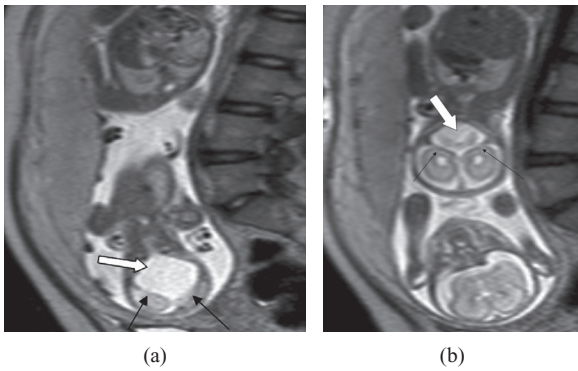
Fetal MRI of twin pregnancy T2 weighted image coronal plane (a) Large posterior fossa cyst in the lower located fetal cranium (white arrow). Note that tentorium cerebella is elevated and posterior cranial fossa is enlarged (black arrows). (b) A posterior fossa cyst is also seen in the upper located fetus (white arrow). Tentorium and posterior fossa volumes are normal in this case (black arrows).
